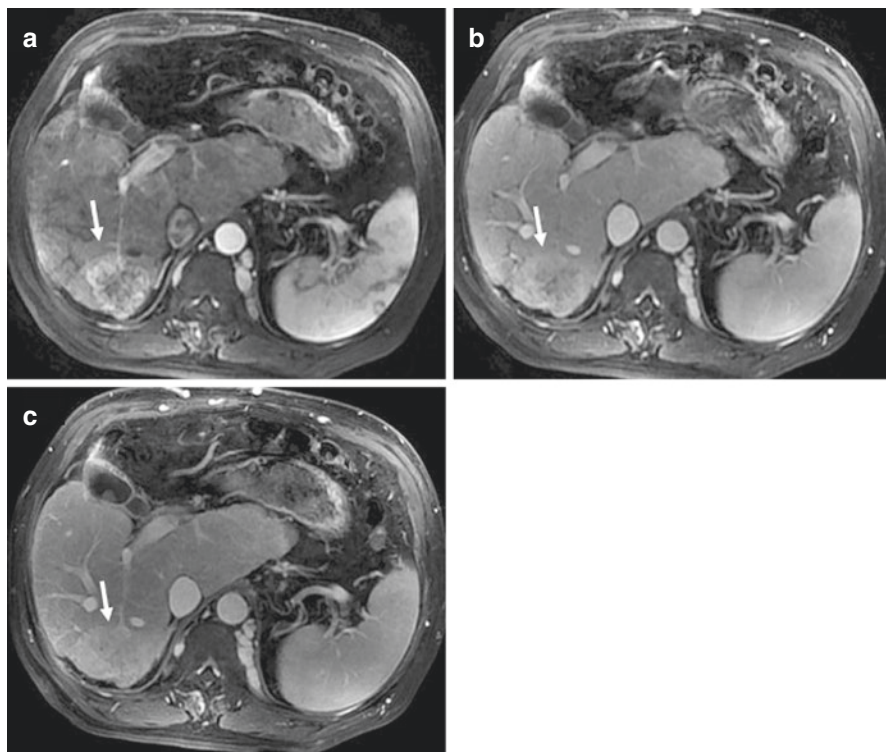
HCC with BCS on MRI: (a) During hepatic arterial phase, lesion (arrow) is hyperintense compared with surrounding liver parenchyma; (b, c). During portal venous phase and equilibrium phase, lesion (arrow) is slightly hyperintense compared with surrounding liver parenchyma [30]
